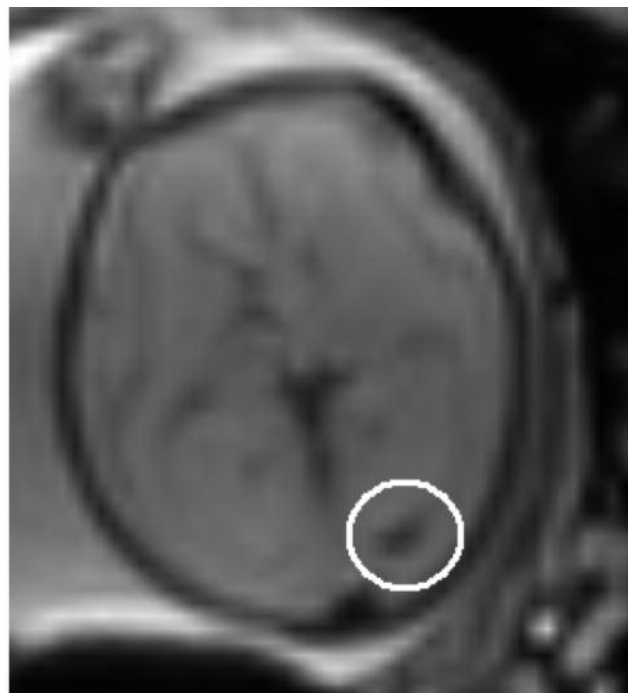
MRI axial view of supratentorial ventriculomegaly (gestational age 24 weeks) with small blood remnant in the left posterior horn, best depicted on a dedicated sequence (right) and barely visible on the conventional T2 image (left).
